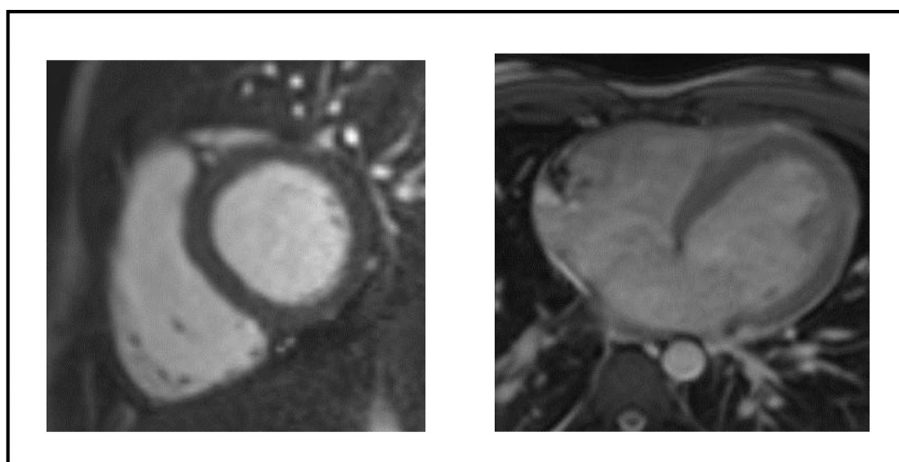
Cardiac MRI on admission to ICU, without evidence of early gadolinium enhancement.
